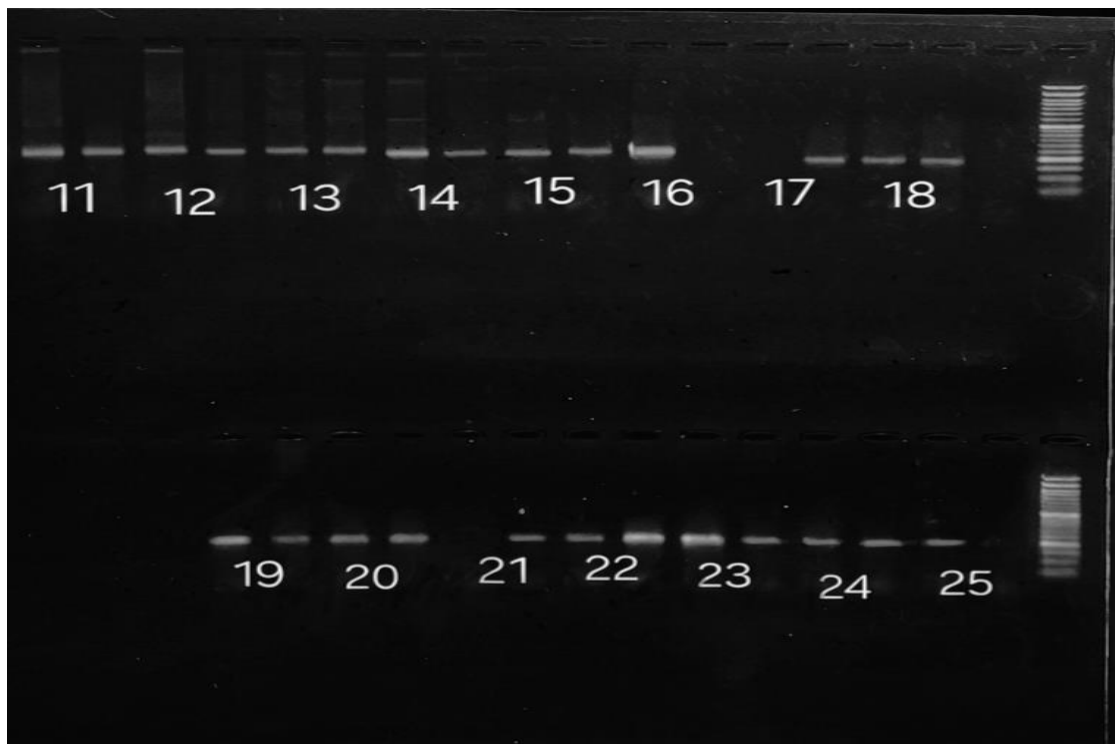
Agarose gel electrophoresis of PCR products for the TMPRSS6 (A736V) polymorphism in chronic hemodialysis (CHD) patients. Most samples showed a heterozygous CT genotype, while sample 16 was homozygous CC and samples 17 and 21 were homozygous TT.
